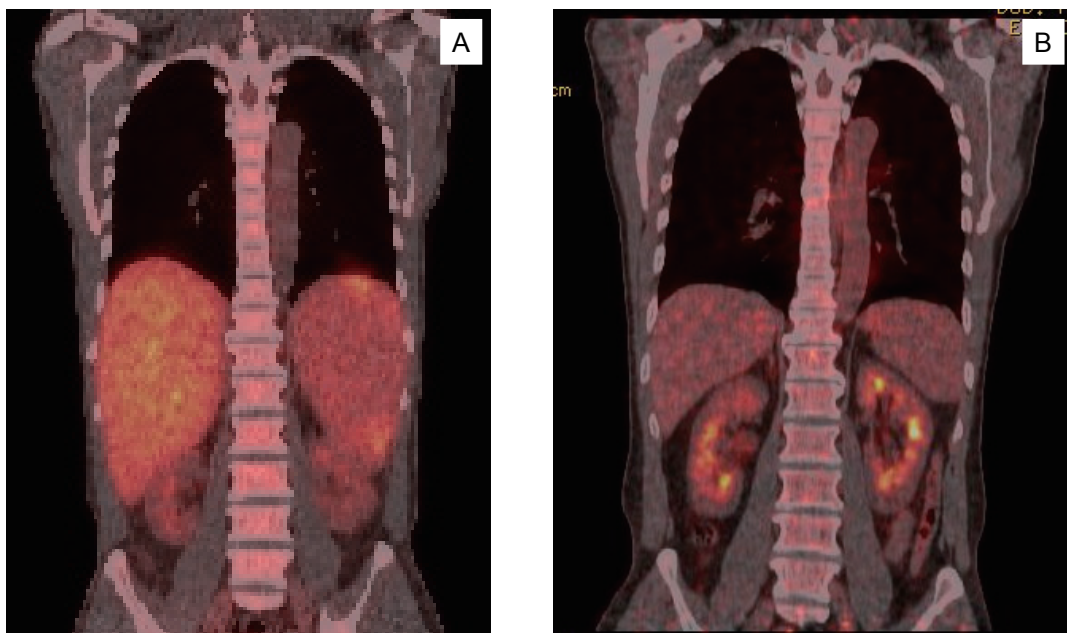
(A) ^{18}F -FDG PET/CT showed marked hepatosplenomegaly at the diagnosis, and (B) the liver and spleen normalized in size after five cycles of CHOP treatment.
